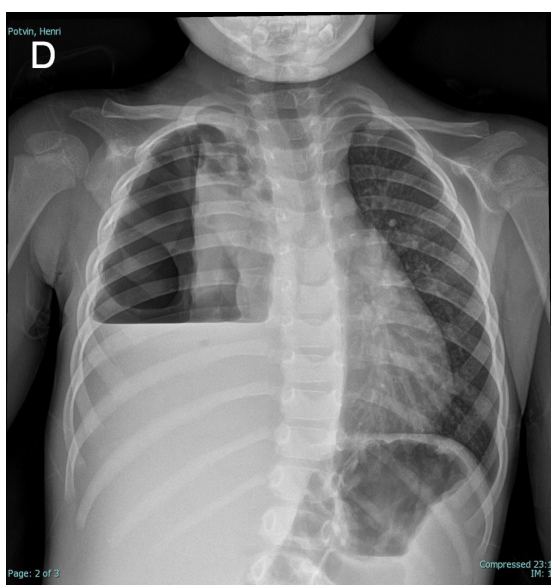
Chest radiograph performed as part of his initial evaluation revealed a large right-sided hydropneumothorax.
